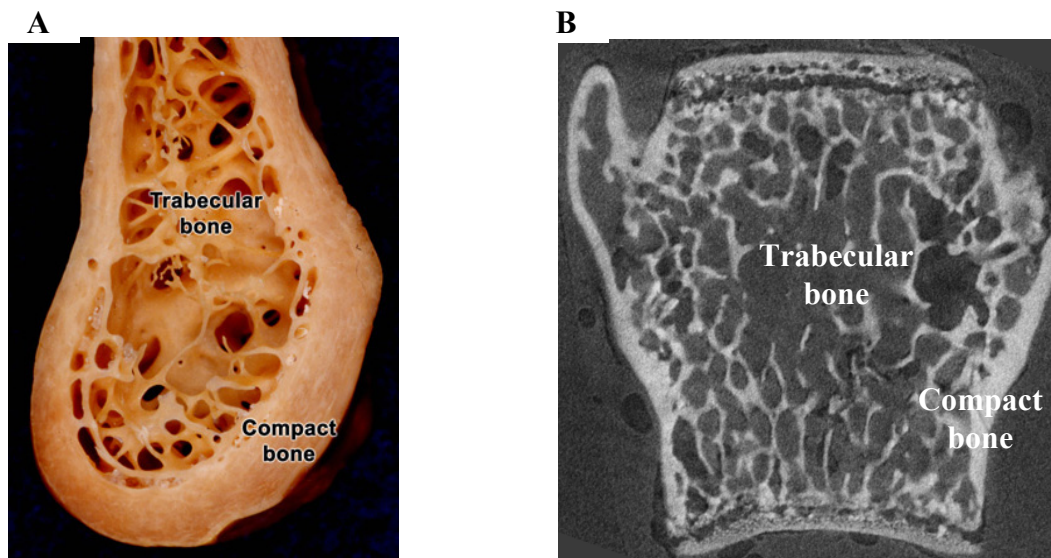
A. Body of the mandible [7]. B. Coronal section of a thoracic vertebral body, obtained with microcomputed tomography.
